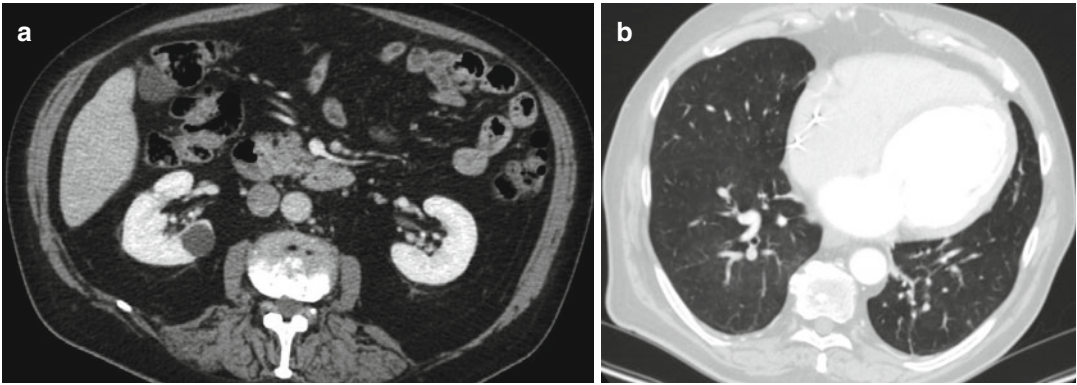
(a, b) Chest–abdomen CT with contrast, with completely normal appearance
